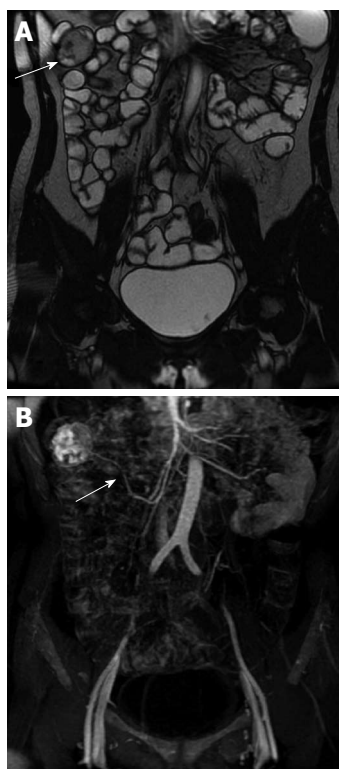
Gastrointestinal stromal tumor of the ileum in a 52-year-old woman who presented with persistent abdominal pain and hematochezia. A: Gadolinium-enhanced T2-weighted image shows a well-circumscribed mass with heterogeneous intermediate signal intensity (white arrow); B: MIP image shows the tumor was supplied by the superior mesenteric artery (white arrow). MIP: Maximum intensity projection.
